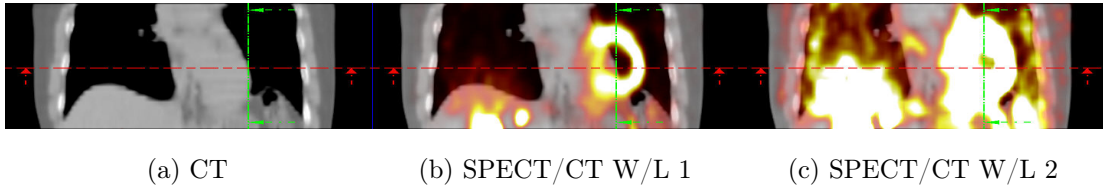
Three anterior views of a misaligned cardiac SPECT/CT data set, the CT (a), and the SPECT overlayed on CT with two different window level settings 1, (b) and (c). The figure visualizes the challenging multi-modal registration problem.
